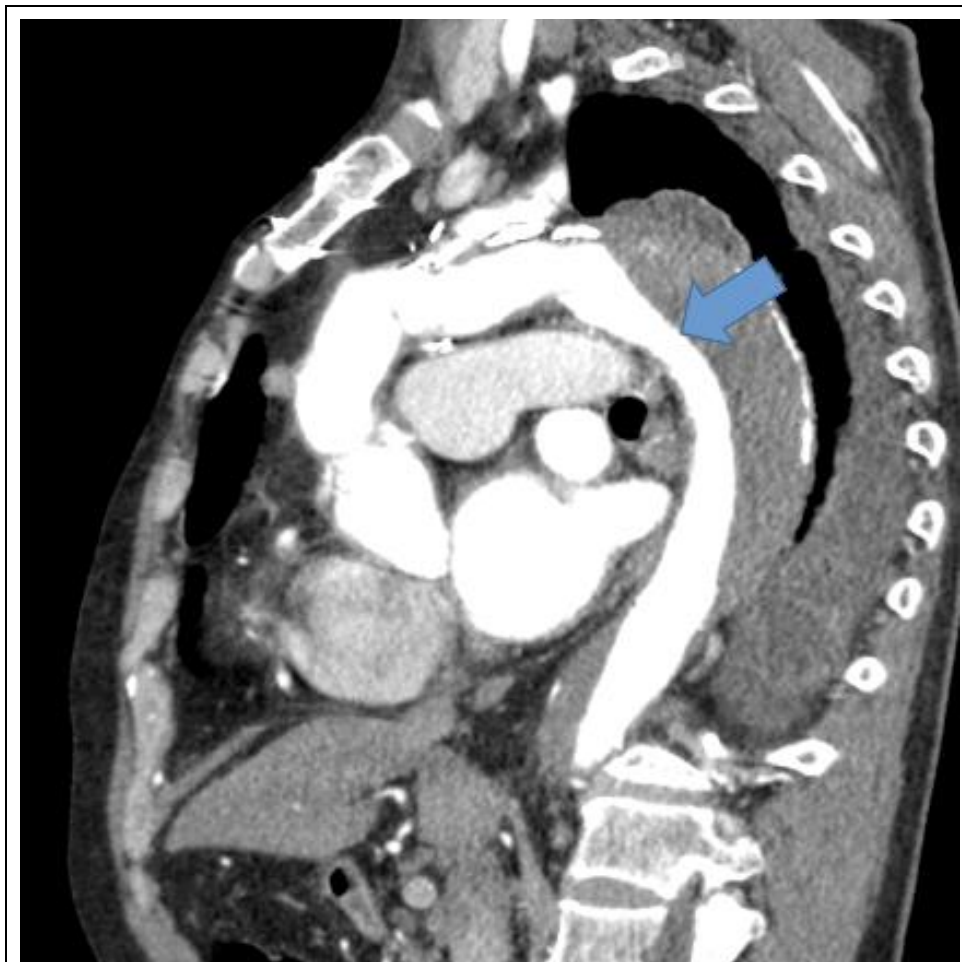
Computed tomography (CT) detected ET stenosis at the distal aortic arch (blue arrow).
